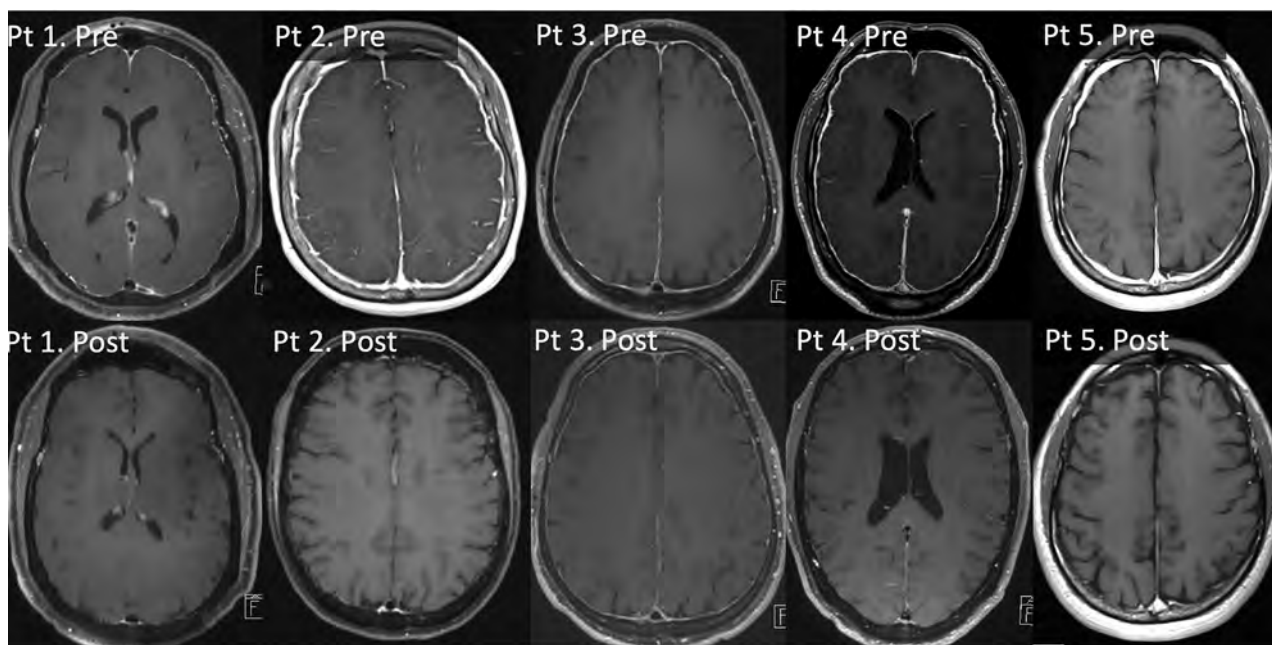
Pre- and posttreatment postcontrast T1-weighted MRIs in patients 1–5. Pretreatment MRIs show diffuse pachymeningeal enhancement in all 5 patients. Posttreatment, there is complete resolution of pachymeningeal enhancement in patients 1, 2, 4, and 5, with subtle pachymeningeal enhancement in patient 3. Pt indicates patient; Pre, pretreatment; Post, posttreatment.
